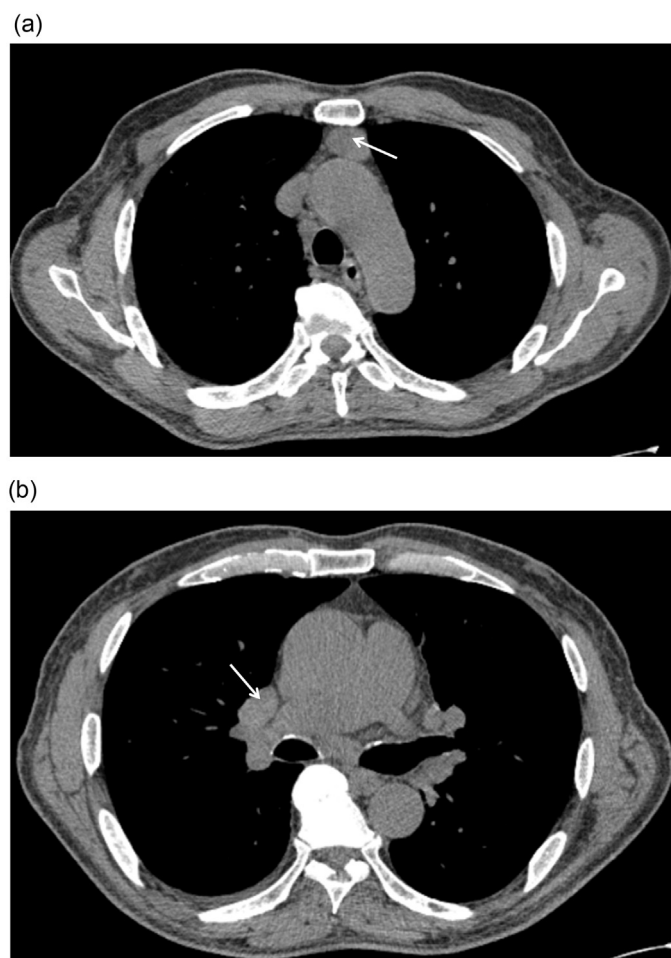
Axial nonenhanced thoracic CT images showing mediastinal lymphadenopathy (with arrows).
